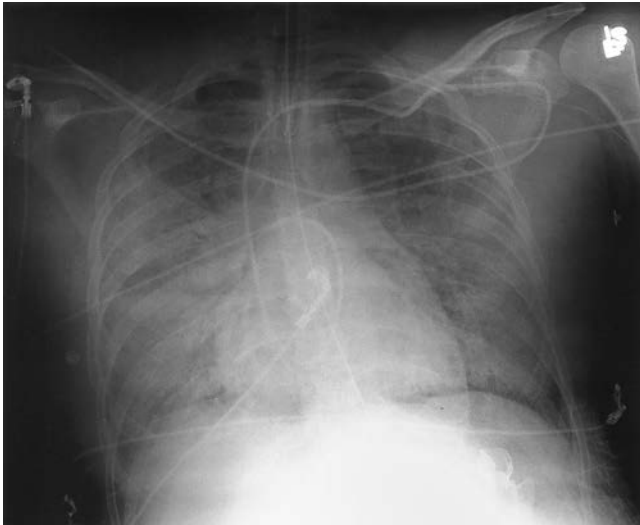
Chest radiograph showing diffuse bilateral infiltrates, consistent with acute respiratory distress syndrome.
